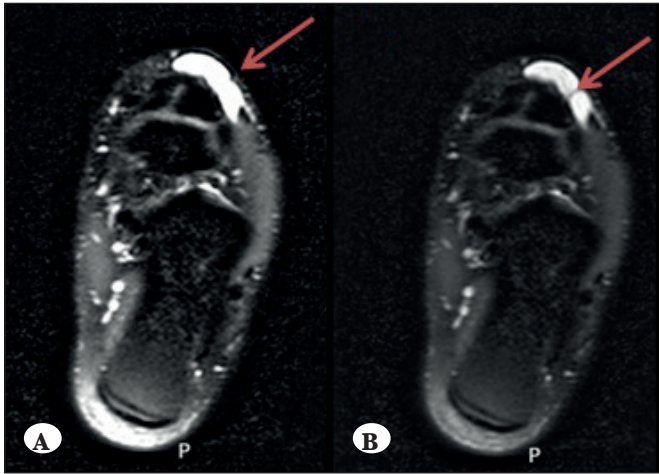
A,B Red arrow shows the lobular ganglion cyst in transverse MRI.
